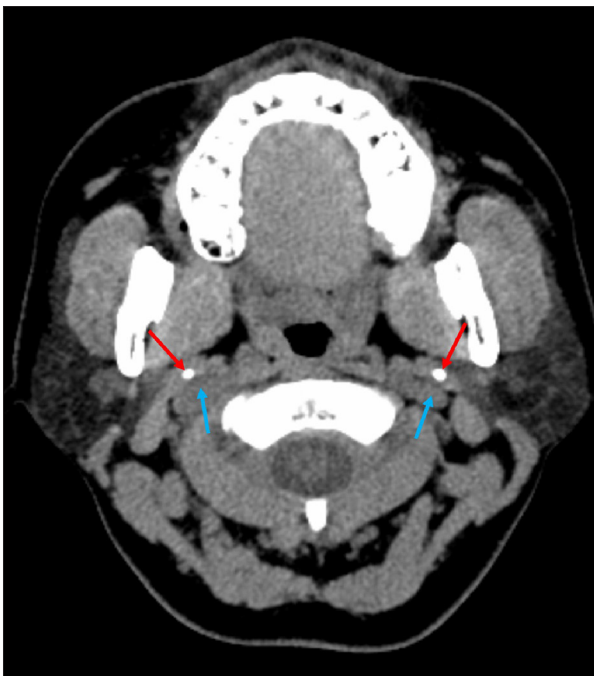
Axial view of the non-contrasted CT of the neck showing bilateral elongated styloid processes (red arrows) that were in close proximity with the internal jugular vein (blue arrows).
